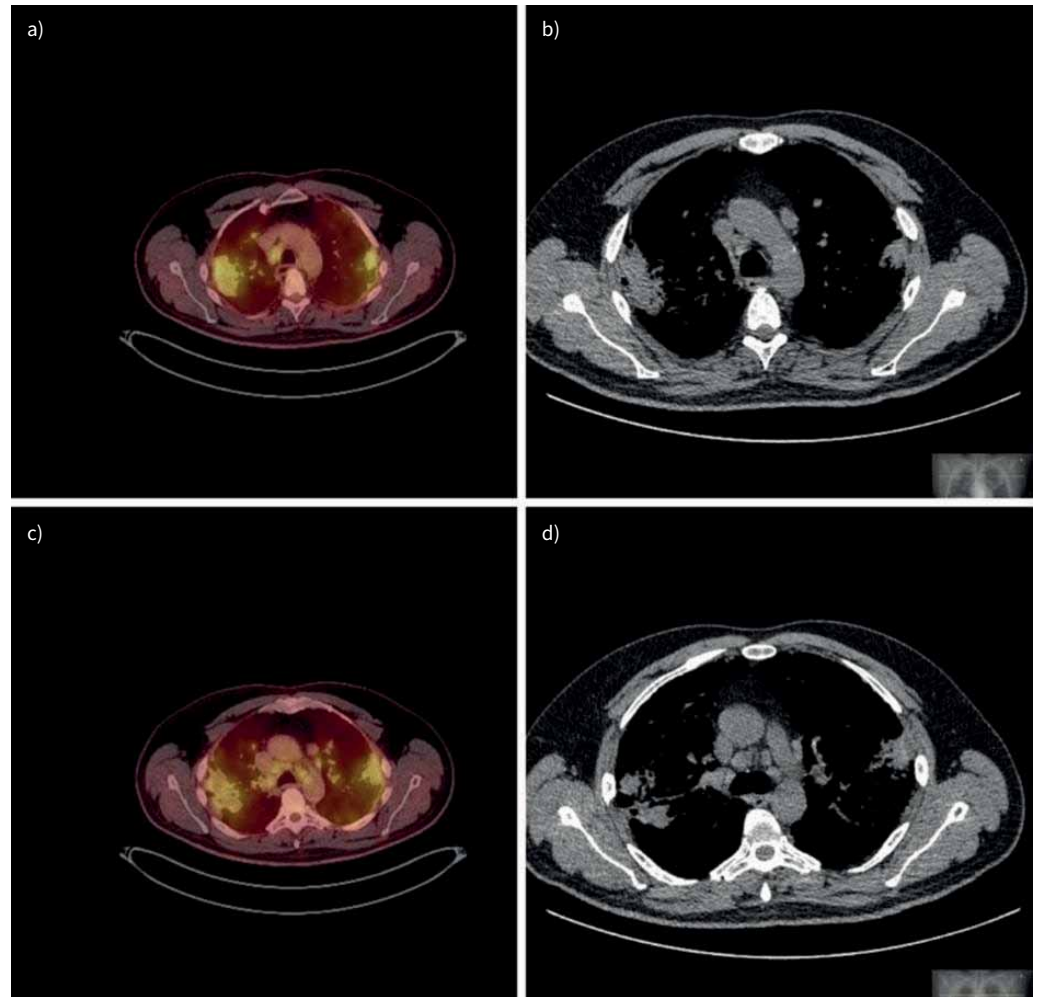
Positron emission tomography computed tomography scan showing avid mediastinal lymphadenopathy and upper lobe consolidations. a–d) Different cross sections.
